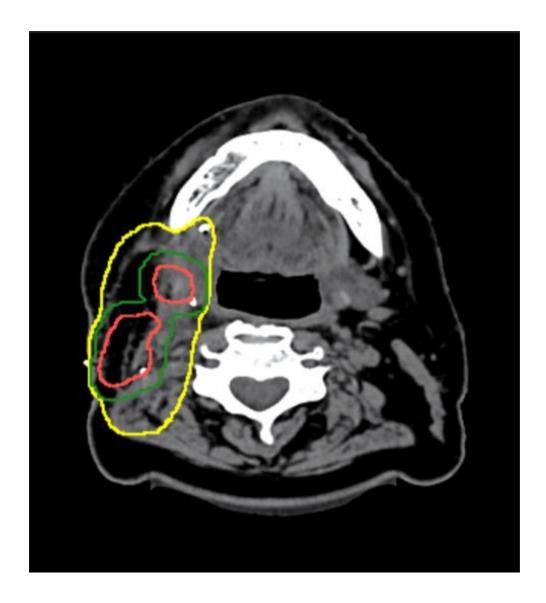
Post-operative Target Volumes and CT axial image at the level of cervical levels III and V region
